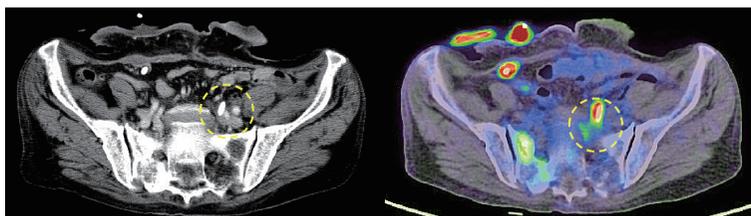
The local re-recurrence was suspected at anastomotic site of left ureter and the ileal conduit by CT and PET
